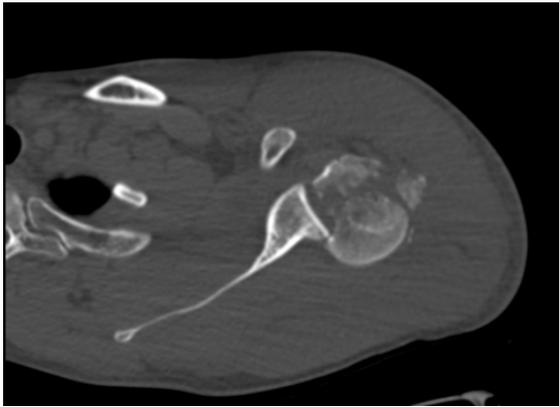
Computed tomography scan of the posteriorly dislocated proximal humerus fracture with fragment engaged on glenoid.
